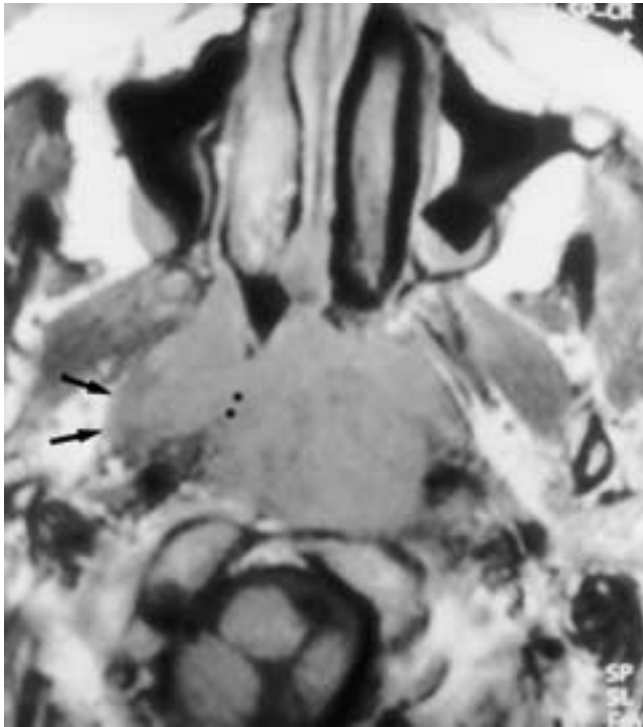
Axial noncontrast, T1-weighted image shows lateral extension of a nasopharyngeal cancer into the superior portion of the parapharyngeal space (arrows) through the expected location of the sinus of Morgagni (*).
